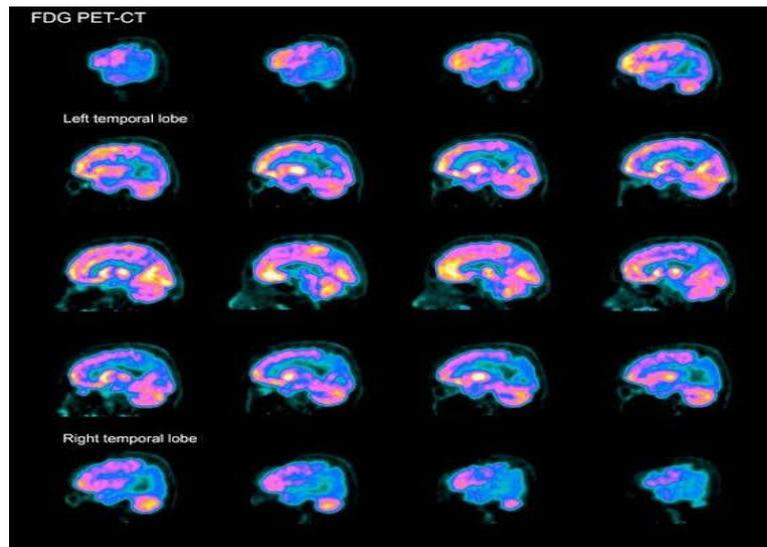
CT scan report of Alzheimer Disease across sectional images of brain (12).
